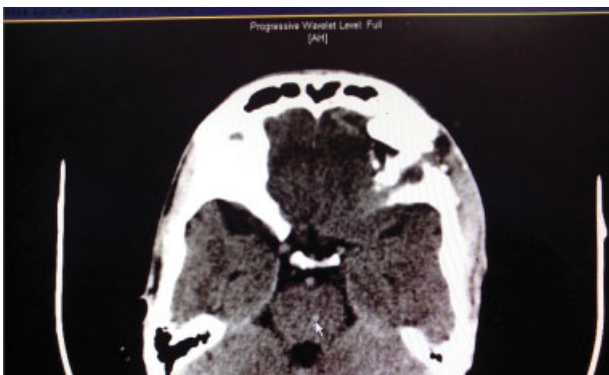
Postoperative, noncontrast computed tomography head, showing complete removal of foreign body.
